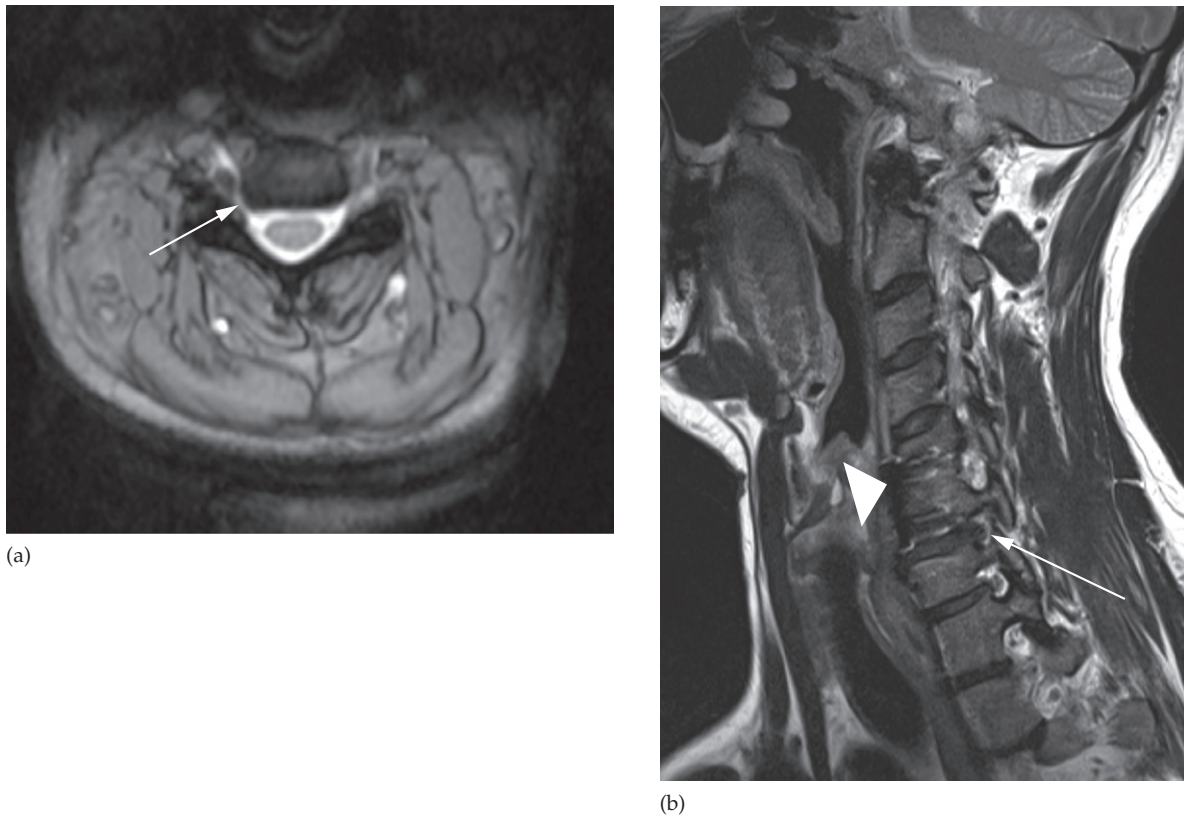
Cervical spondylosis. (a) Axial T2-weighted MRI of the cervical spine showing a combination of disc protrusion and osteophytes causing narrowing of the right exit foramen (arrow). (b) Sagittal oblique T2-weighted MRI of a different patient with a previous anterior spinal fusion (arrowhead) and a disc protrusion causing narrowing of the C6/C7 exit foramen (arrow).
